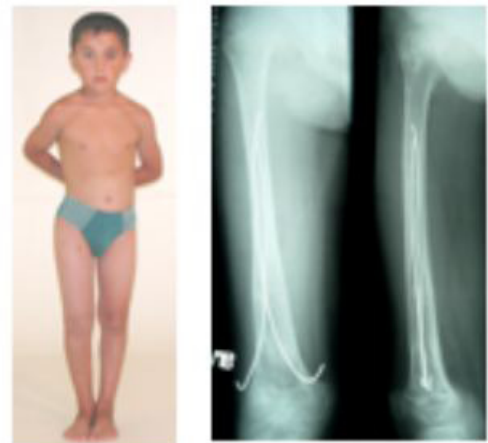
Photo and X-rays of patient 8-years-old as the result of limb lengthening by combined osteosynthesis.
